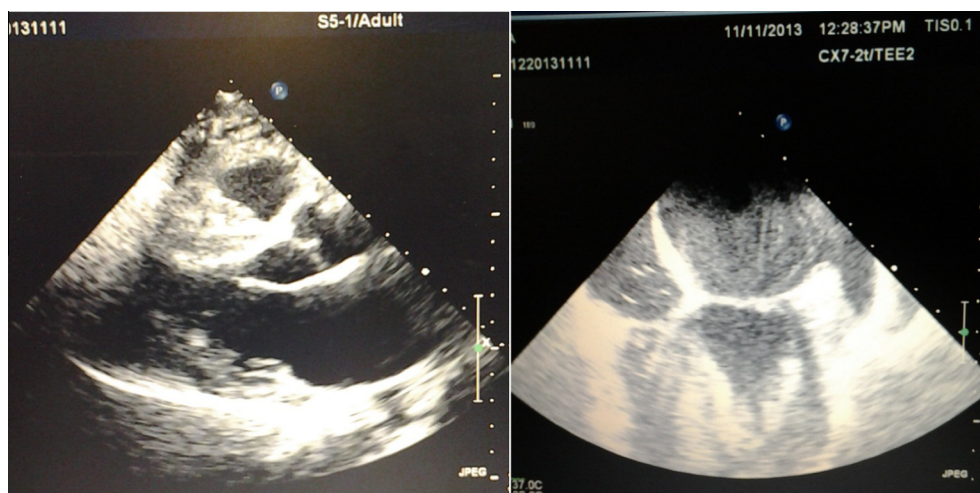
Echocardiogram showing 'speckled' thickened interventricular septum and dilated left atrium with swirling 'spontaneous echo contrast'.
